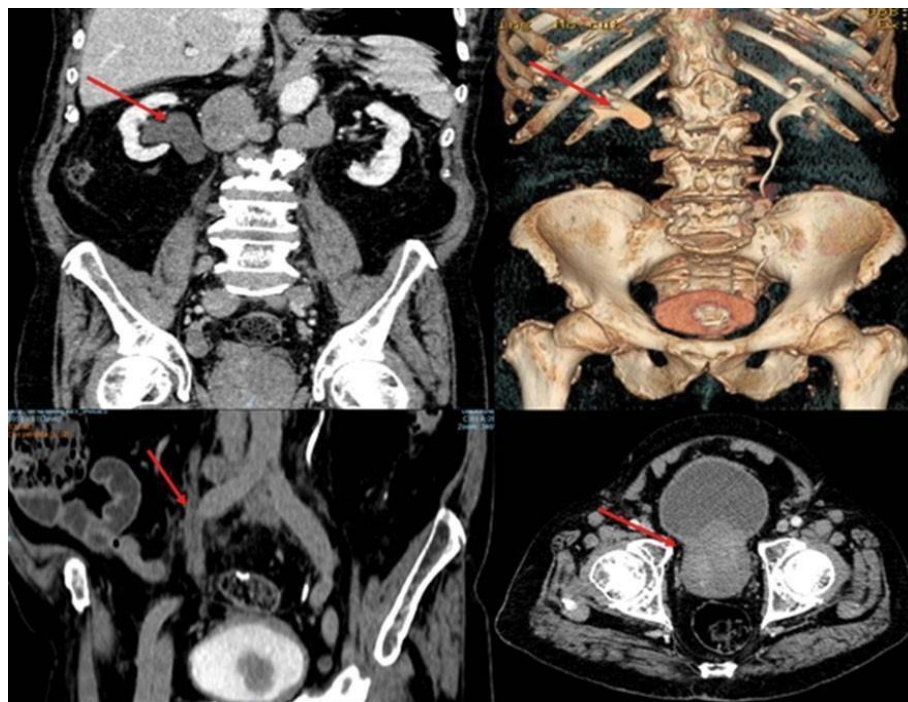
(A) Right uretero-hydronephrosis in conventional CT image; (B): Right uretero-hydronephrosis in uro-CT with 3D reconstruction, compared to healthy left pyelocaliceal system; (C): Possible single, isolated and localized metastatic deposit, which conditions luminal stenosis and secondary obstruction; (D): Enlarged prostate, retrovesical and pararectal adenopathic conglomerates
